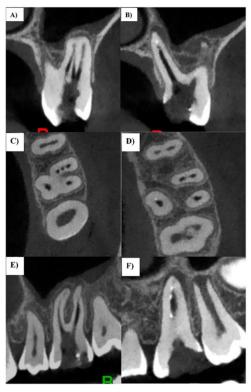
Sagittal section of mesiobuccal root showing three canals, B) Sagittal section of palatal root. C) and D) are CBCT axial sections along the cervical and apical aspects of the roots respectively. E) and F) are CBCT coronal sections, E) mesiobuccal and distobuccal roots, F) palatal root.
